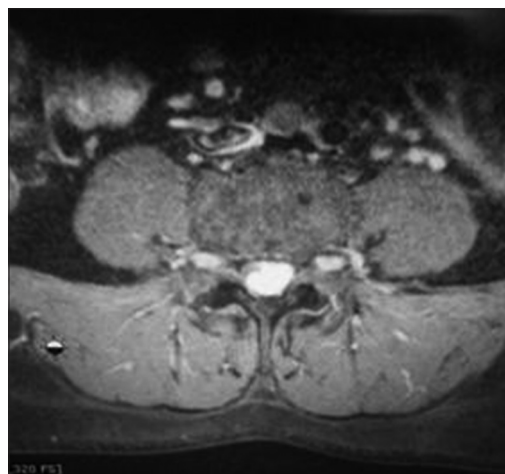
Postcontrast axial T1-weighted sequence
